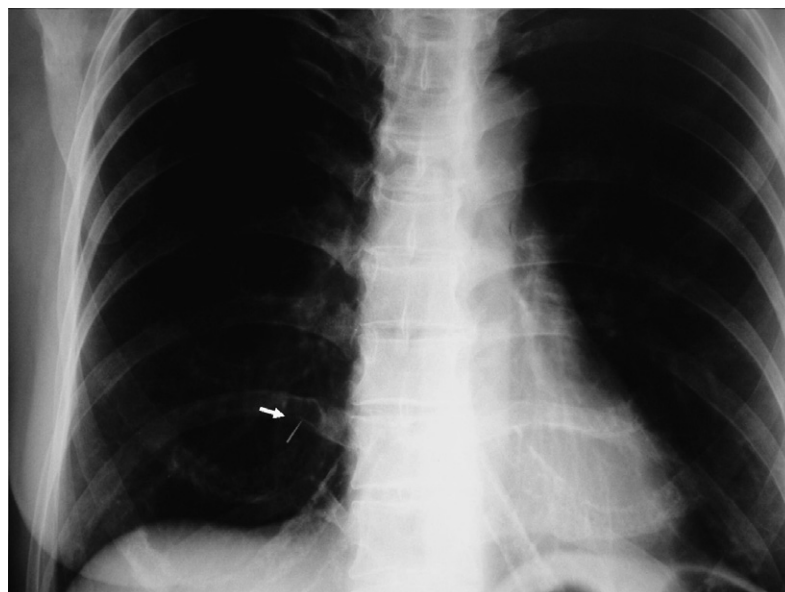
Normal chest radiograph showing a self-penetrated foreign body (needle) in the right breast region.
